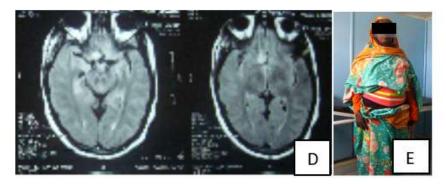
Image (D) is post-operative MRI showing complete resection of the tumor, Image (E) is the patient after complete recovery 3 months post-operatively.
